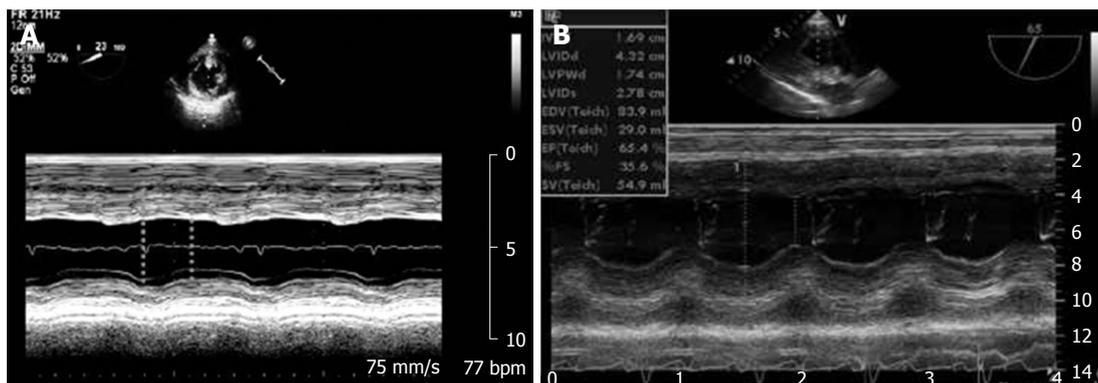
Transesophageal measurements of fractional shortening. A: TG Mid SAX view of the left ventricle showing M-mode measurement of LVEDD and LVESD normalized for LVEDD. The bidimensional image is usually best imaged at a multiplane angle of 0°; B: TG LAX view of left ventricle showing M-Mode measurement of LVEDD and LVESD normalized for LVEDD usually best imaged at an angle of approximately 80°-110°. LAX: Long axis view; TG: Transgastric; LVEDD: Left ventricle end diastolic diameter; LVESD: Left ventricle end systolic diameter. Modified by Guarracino Fabio *et al.*^[61].
